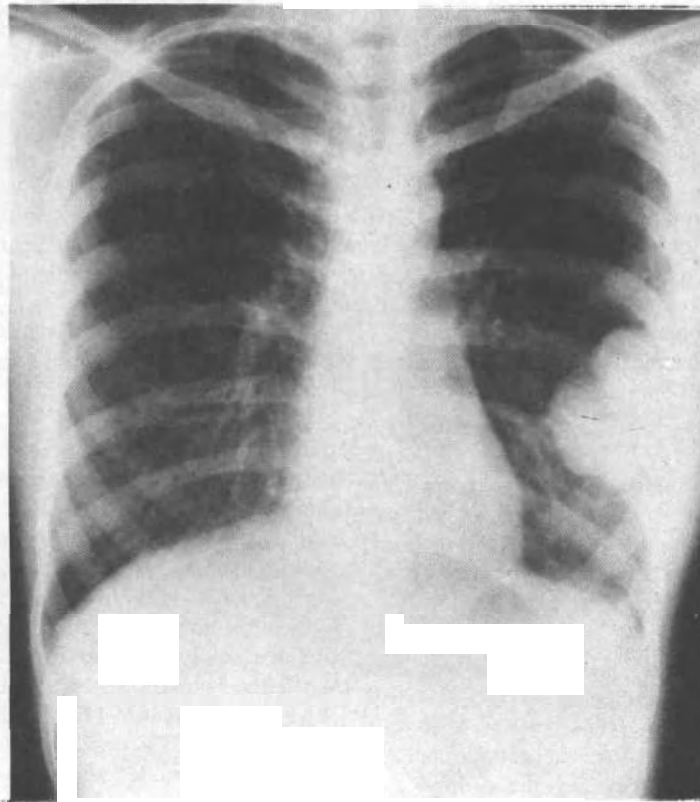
Chest radiograph showing lobulated mass arising from left sixth rib.
